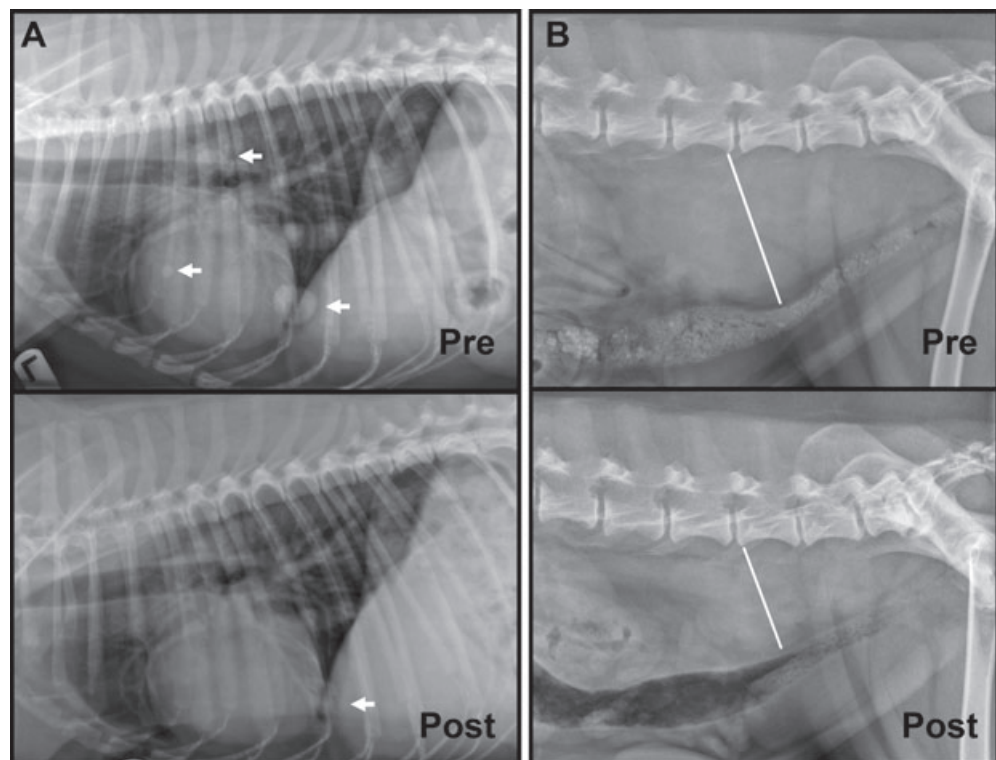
Response of AGASACA to toceranib. (A) An 8-year-old MC mix breed with metastatic AGASACA to the sublumbar lymph nodes and lungs was treated with toceranib after recurrence postsurgery, radiation therapy and chemotherapy. Pictured above are radiographs before the start of Palladia and again at day 46 of therapy. Regression of several pulmonary metastatic lesions is noted. (B) A 9-year-old spayed female Golden retriever with metastatic AGASACA to the iliac lymph nodes, retroperitoneal space and lungs was treated with toceranib after having failed surgery and multiple rounds of chemotherapy. Shown is a radiograph of her caudal abdomen before toceranib administration, and then again 4 weeks later demonstrating regression of her iliac lymph nodes. She also experienced regression of her pulmonary nodules (not shown).
